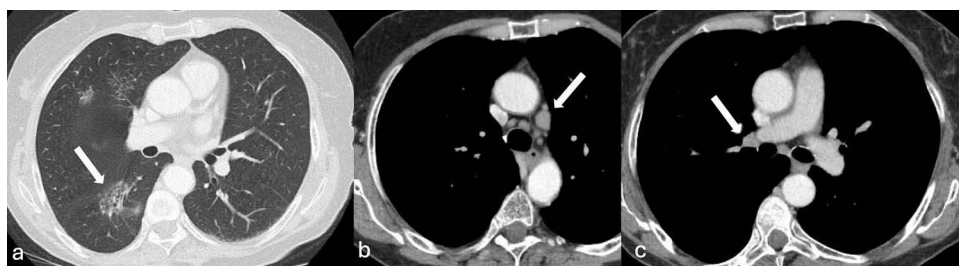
3-month follow-up chest CT showing significant interval decrease of the right lower lobe mass with a residual groundglass opacity (white arrow on (a)), similar to the pre-existent multifocal lesions, and persistent prominent subaortic (b) and right hilar (c) lymph nodes (white arrows on (b) and c)).
